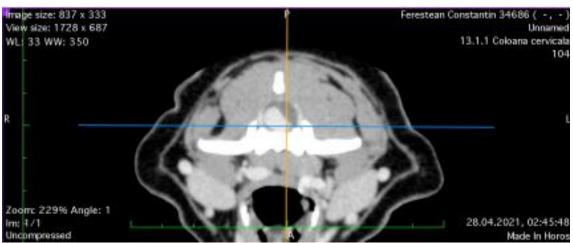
Axial CT image invasive lesion at the level of intramedullary canal with the appearance of a mass on the C2 segment;
